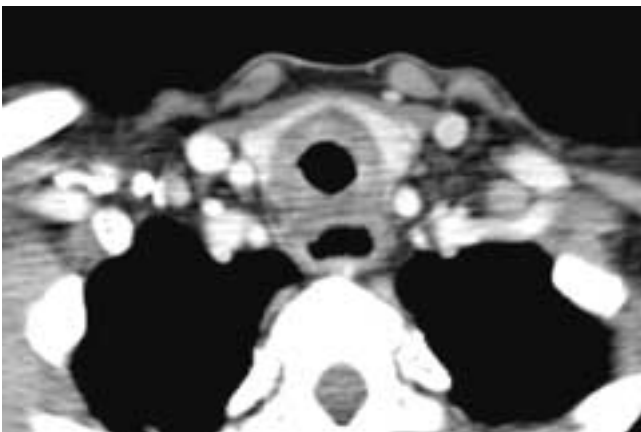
Axial contrast-enhanced CT scan shows a circumferential tracheal stenosis corresponding to the type of injury shown in [Figure 31-19](#). The thyroid gland surrounds the anterior and lateral aspects of the trachea.
